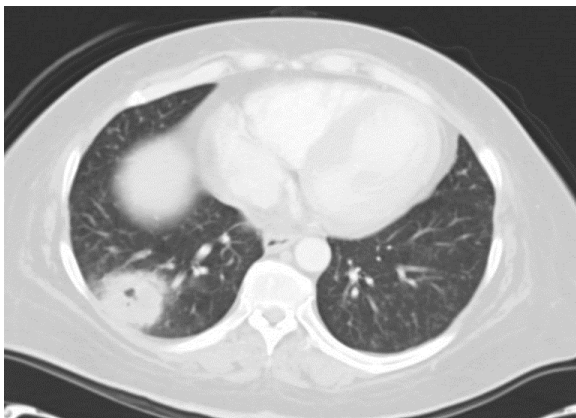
CT chest demonstrating a right lower lobe coccidioidal pulmonary cavity, in the setting of miliary Coccidioidomycosis.
